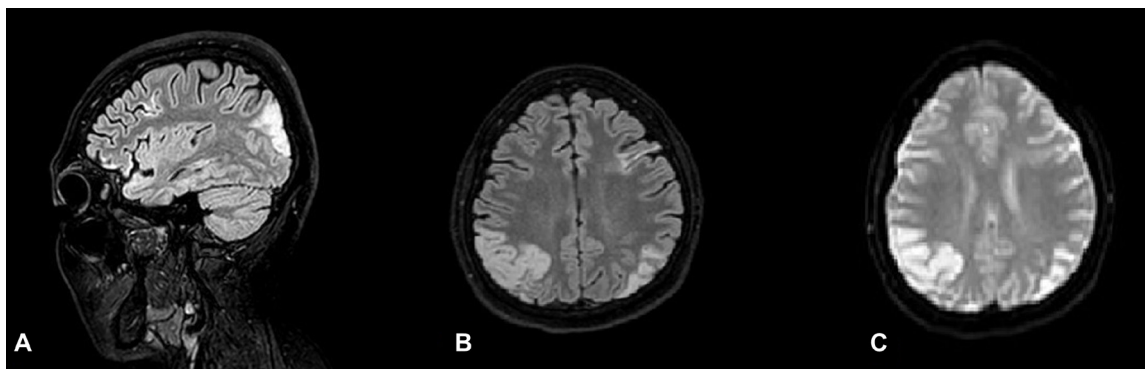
Magnetic Resonance Imaging of subject's brain showing bilateral parieto-occipital hyperintensities in FLAIR (A, B) as well in DWI (C) sequences compatible with oedema due to PRES.
